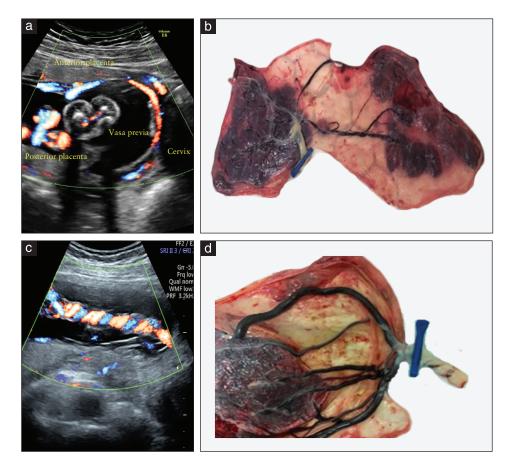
Vasa previa with bilobed placenta (a,b) and velamentous cord insertion (c,d), demonstrated by color Doppler ultrasound images (a,c) and gross placental appearance (b,d).
